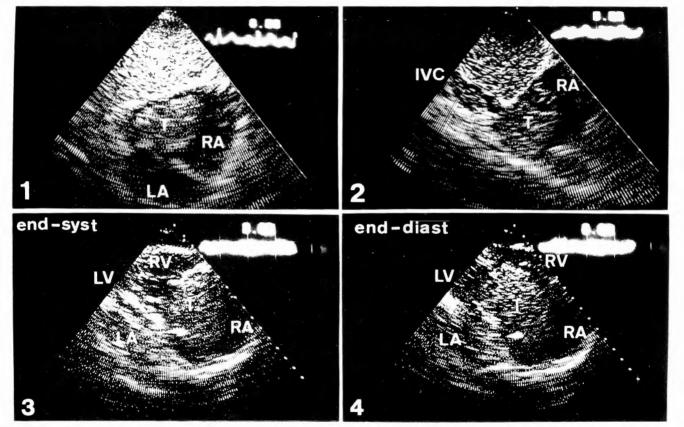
Two-dimensional echocardiograms obtained from various approaches- xyphoid approach (1 and 2) and apical four chamber view (3 and 4) T: tumor, RA: right atrium, LA: left atrium, IVC: inferior vena cava, RV: right ventricle, LV: left ventricle
